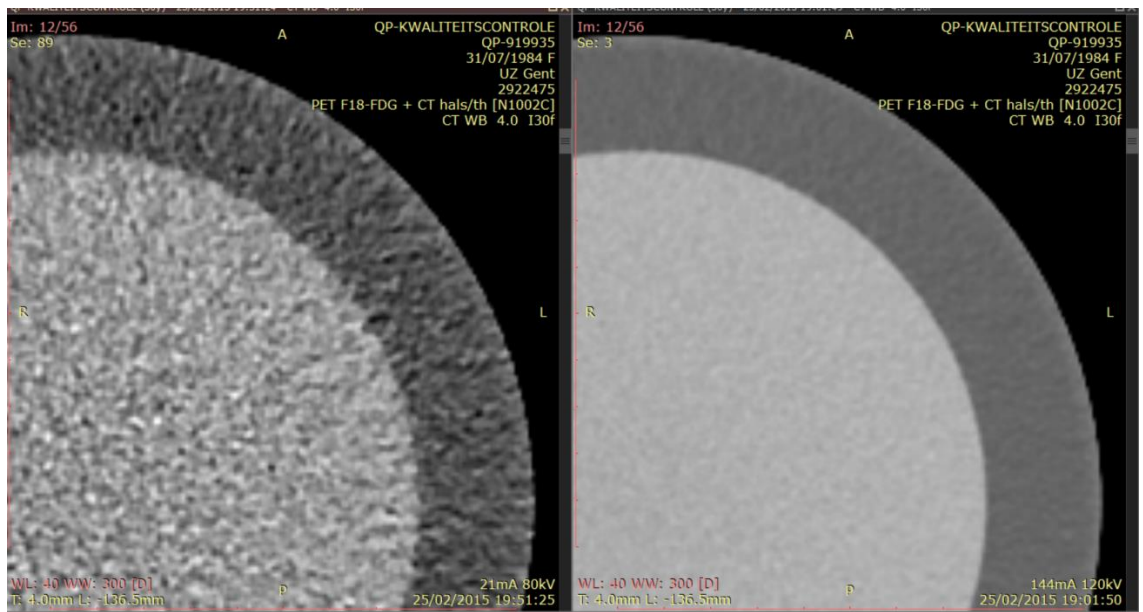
Visualization of noise in two CT images. On the left a noisy image of 80 kV and 15 mAs, on the right a noise free image of 140 kV and 71 mAs
